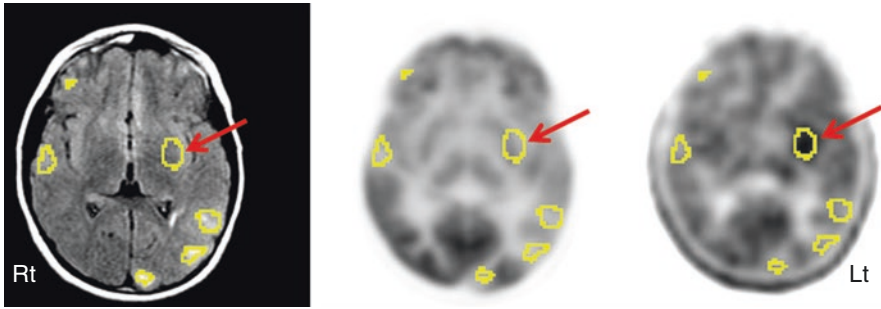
FLAIR MRI (*left image*), 2-deoxy-2-(^{18}F)-fluoro-D-glucose (*middle image*), and ^{11}C -alpha-methyl tryptophan PET (*right image*) scan in a patient with multiple tubers (*encircled with “region of interests”*), intractable seizures, and non-localizing scalp EEG. While 2-deoxy-2-(^{18}F)-fluoro-D-glucose PET showed hypometabolism in all the tubers and overlying cortices, interictal ^{11}C -alpha-methyl tryptophan PET scan revealed increased alpha-methyl tryptophan uptake in an insular tuber (*arrow*)
